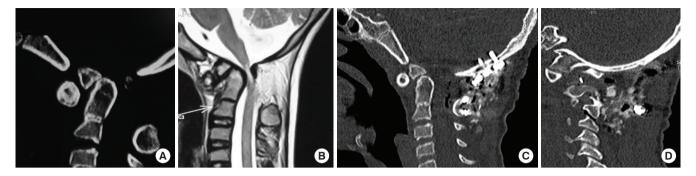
A 9-year-old-boy tripped over the ground running while playing cricket 4 months ago (case 4, Table 1). He developed a type I dens fracture (fracture of os odontoideum; A). Magnetic resonance imaging (B) showed severe compression of the cord between the body of C2 and the C1 arch. A modified distraction, compression extension, and reduction (DCER) was necessary as the fractured fragment was in front of the C2 body. Following a modified DCER, there was a satisfactory reduction of the fracture (C). Panel D shows the polyetherethereketone cage placed between the occiput and C2 facet.
